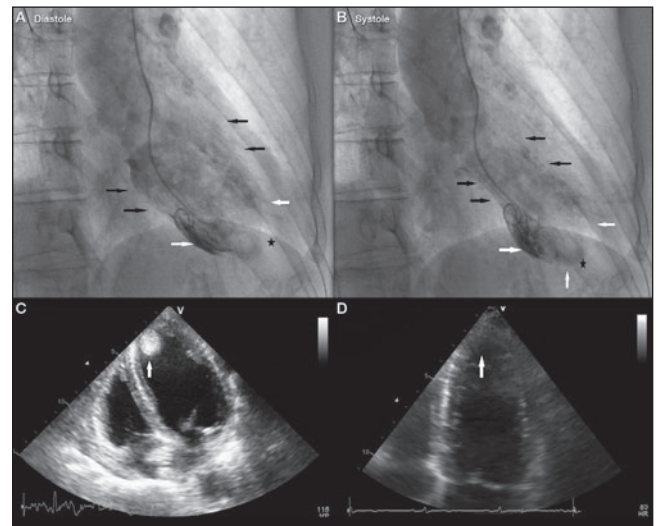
A Left ventriculogram in diastole showing normal appearing left ventricular (LV) endocardium at base (black arrows) and apex (white arrows) of heart with apical thrombus (star). B Left ventriculogram in systole showing normal contracting base (black arrows) with akinesia and ballooning of apex (white arrows) suggestive of Takotsubo cardiomyopathy. C Echocardiogram showing LV apical thrombus (white arrow) in apical four-chamber view at initial presentation. D Echocardiogram showing resolution of apical thrombus (white arrow) in the apical four-chamber view eight weeks later
